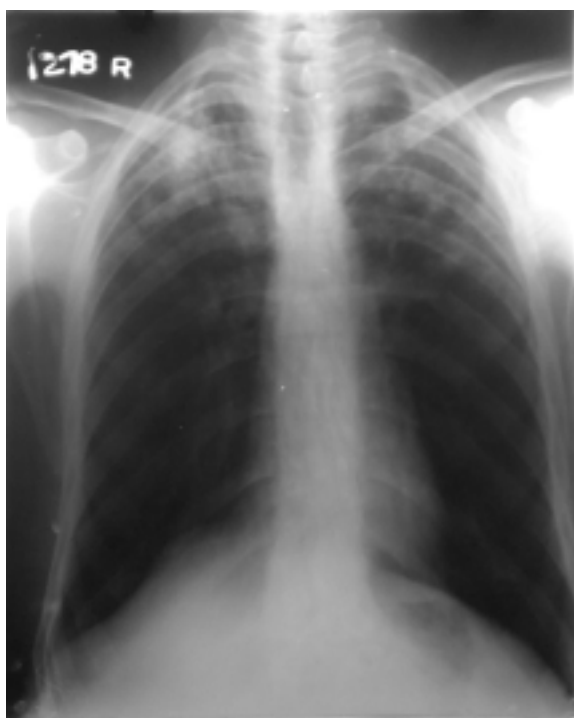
X-ray chest of patient showing bilateral inhomogenous infiltrates at upper and mid zones.
